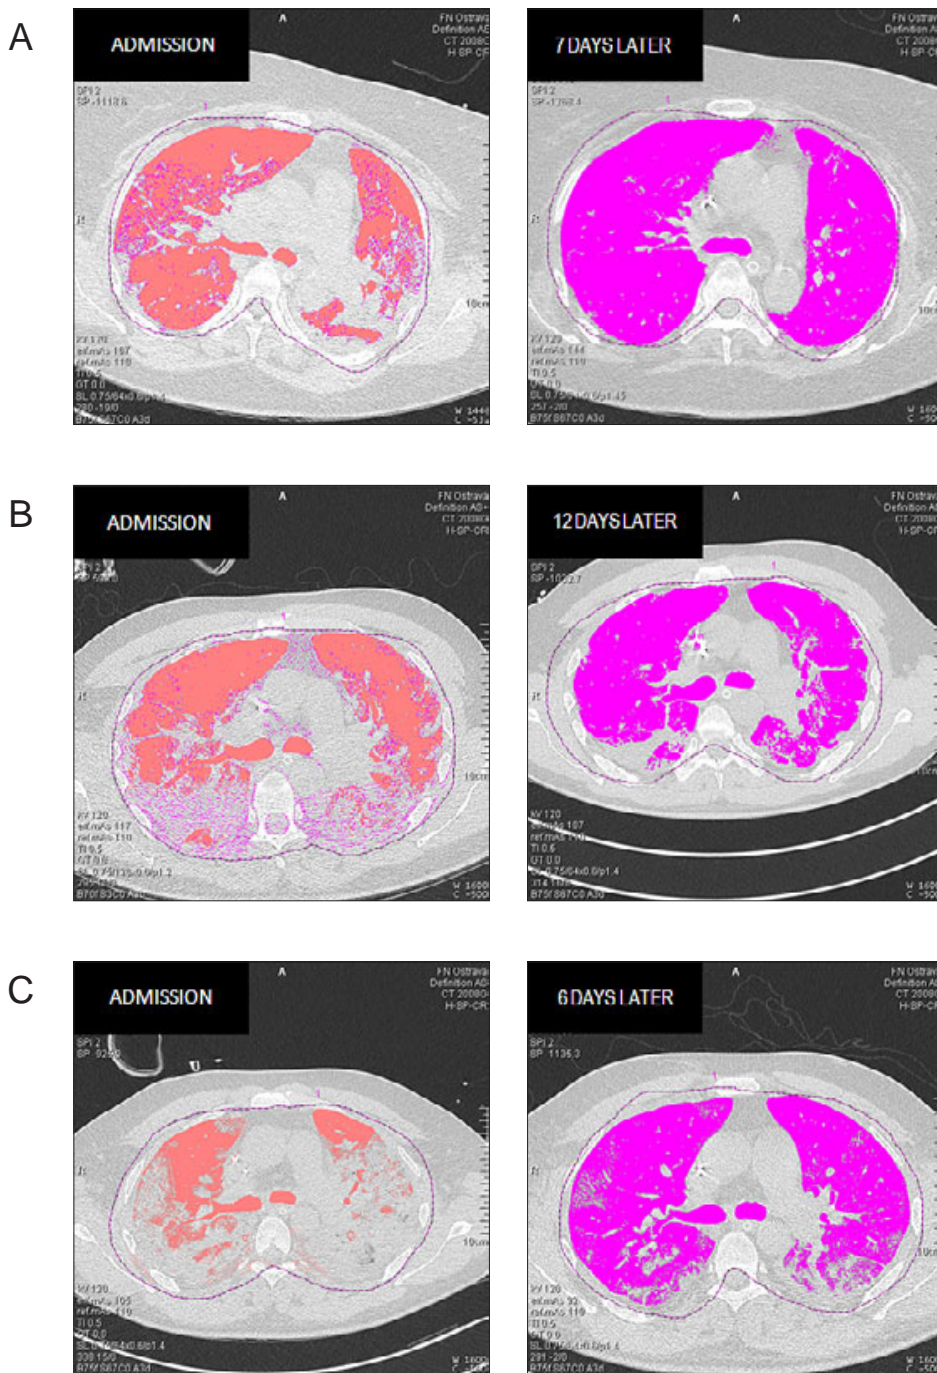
The changes in CT-findings related to lung airspace volume. Legend: A – Case 1, B – Case 2, C – Case 3 (for calculation of the lung airspace value the Syngo Volume Calculation, Syngo CT 2008Gä Siemens was used).
